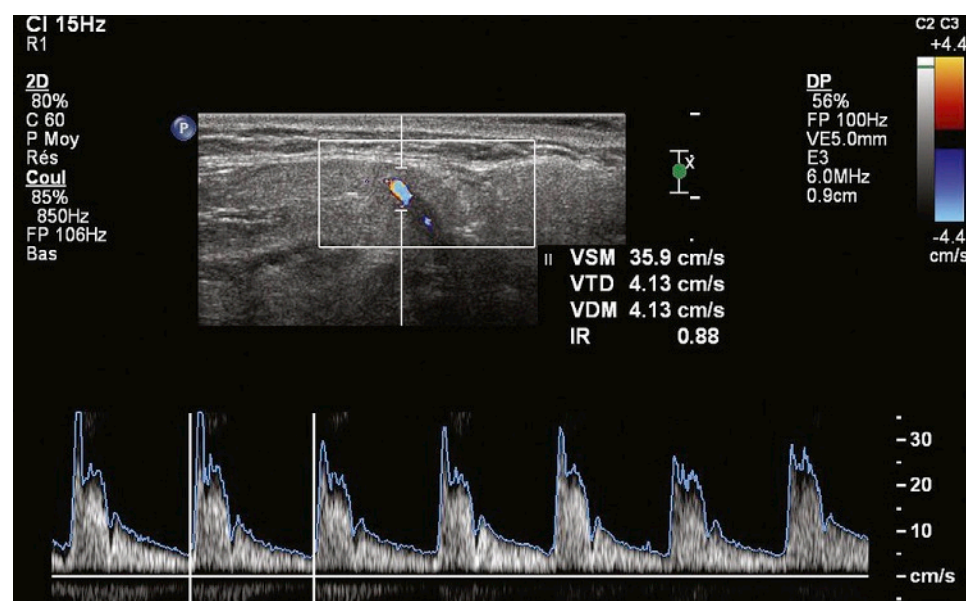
A Doppler waveform is seen on a transverse view of the facial artery of a control before lemon stimulation. The Doppler waveform was typical, with a high systolic peak and a prominent compliance peak, followed by a low diastolic flow (RI = 0.88).
